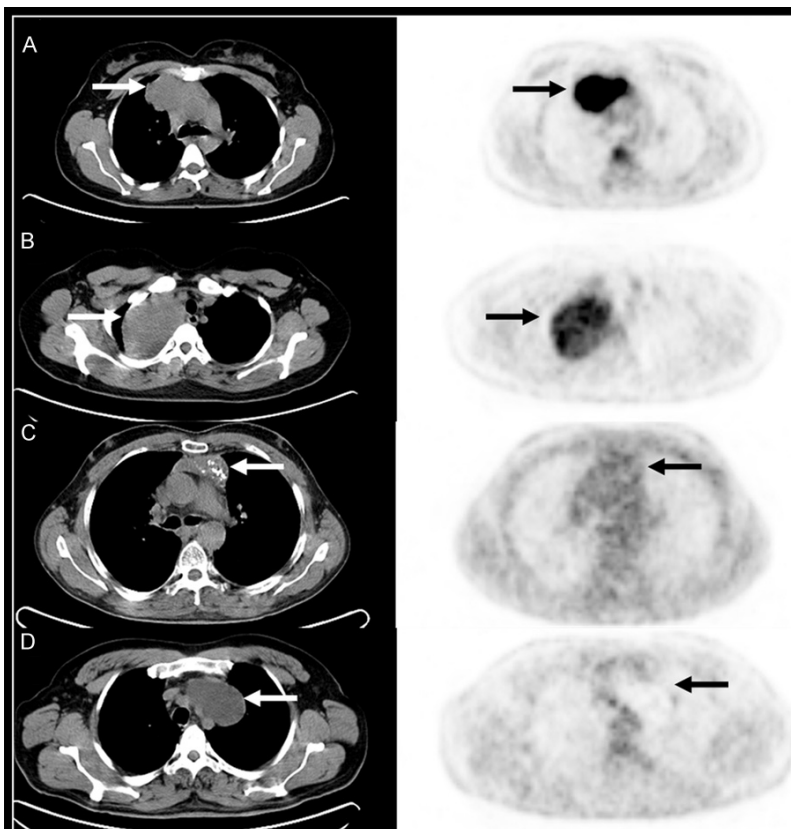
A. True-positive. A 44-year-old-woman with thymic carcinoma. FDG PET/CT images showed a mass in the anterior mediastinum with high FDG uptake ($SUV_{max} = 12.57$) (arrows). B. False positive. A 34-year-old-woman with schwannoma. FDG PET/CT images showed a mass in the posterior mediastinum with moderate FDG uptake ($SUV_{max} = 5.46$). C. False-negative. A 55-year-old man with type B3 thymoma (well-differentiated thymic carcinoma). FDG PET/CT images showed a mass with FDG uptake equal to mediastinum. D. True-negative. A 49-year-old man with parathyroid cyst. FDG PET/CT images showed a photopenic huge mass in the anterior mediastinum.
